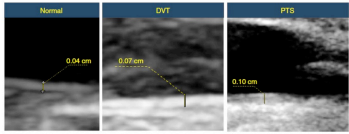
High-resolution ultrasound images demonstrating significant wall thickening in patients with acute deep vein thrombosis (DVT) and postthrombotic syndrome (PTS) as compared with normal. [Color figure can be viewed at wileyonlinelibrary.com]
